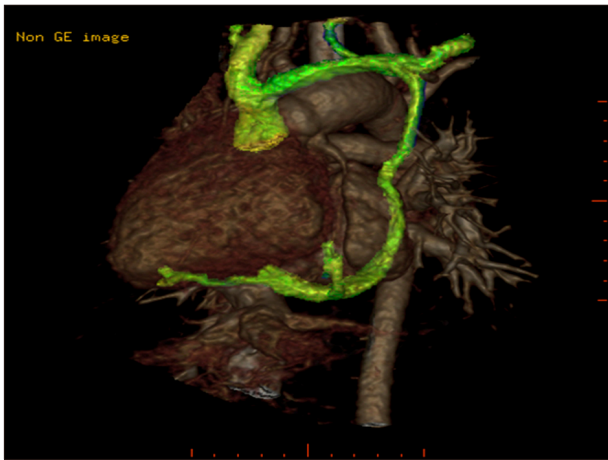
Computed tomography scan showing a dilated coronary sinus and a left superior vena cava to left innominate vein communication.
